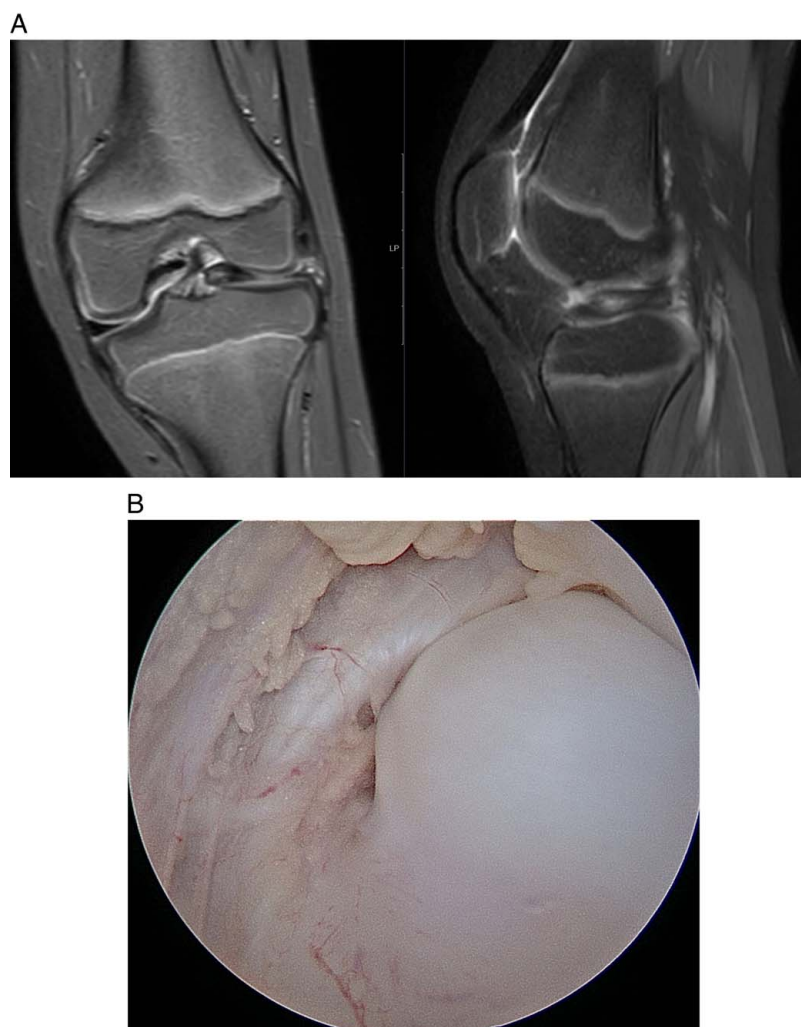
A, MRI depicting complete discoid meniscus with intrabody tear. B, Arthroscopic photo showing the discoid meniscus pressed up against the ACL blocking access to the lateral compartment.
